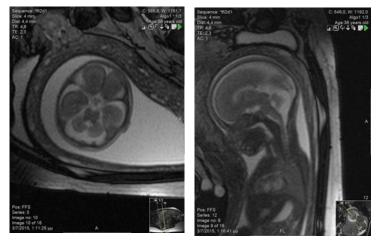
MRI of a fetus brain at 22 WG using axial (a) T2-W and sagittal (b) sequence reveals hypoplastic cerebellar vermis and an enlarged fourth ventricle communicating with the cisterns magna (CM).
